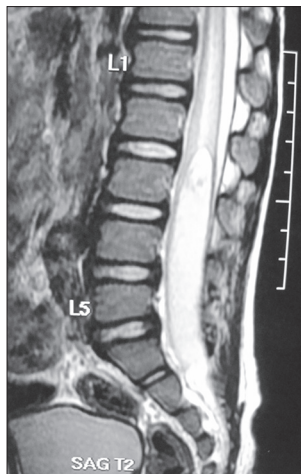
T2-weighted image showing hyperintense lesion
